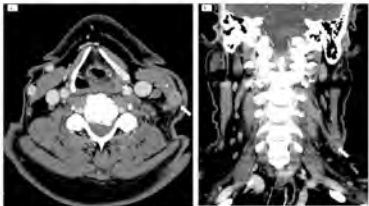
Axial (A) and sagittal (B) contrast-enhanced neck CT of a 72-year-old male patient with recurrent anastomotic SCC of the left upper lip region and a metastatic tumor anterior to the left parotid gland (arrow), demonstrating a necrotic axilla metastasis within the left parotid gland (arrowhead), and a cord-like structure extending inferiorly from the parotid region (arrow) over the oblique sternocleidomastoid muscle representing PNS along the GAN.
